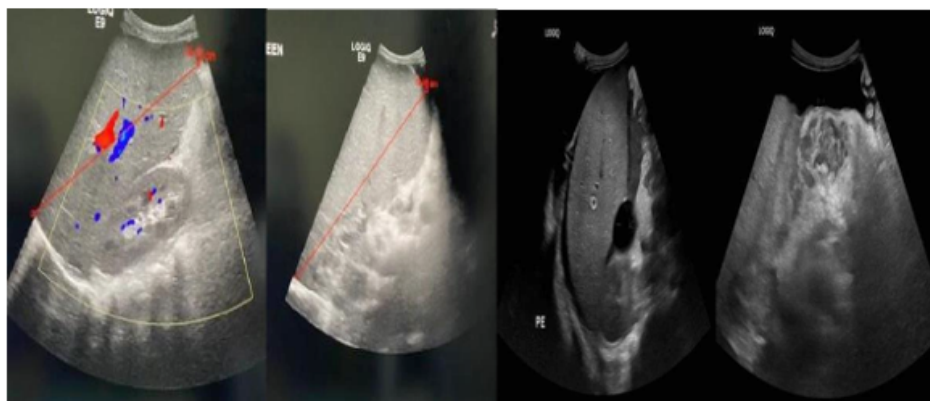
A. Ultrasound of abdomen showing enlarged liver with liver span of 14.03 cm. B. Ultrasound of abdomen showing enlarged spleen 19.45 cm. C. Moderate amount of free ascites fluid noted in the abdomen and pelvis. The largest amount in the left lower quadrant is unchanged compared to previous study.
